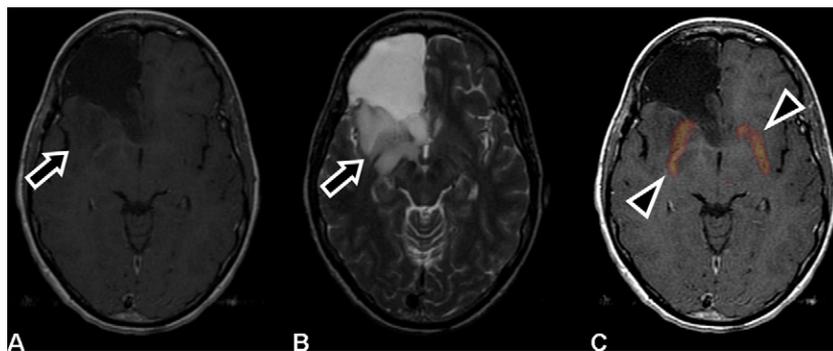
T1W MRI (A) shows area of non-enhancing tumor posterior to the resection cavity (arrow), which can be more clearly seen on T2W MRI (B) (arrow).  $^{18}\text{F}$ -FDOPA-MRI fusion (C) shows no  $^{18}\text{F}$ -FDOPA PET activity in this area of tumor recurrence. The presence of  $^{18}\text{F}$ -FDOPA activity in the basal ganglia (arrowhead) serves as an internal control and confirms that the  $^{18}\text{F}$ -FDOPA labeling protocol had been carried out successfully.
